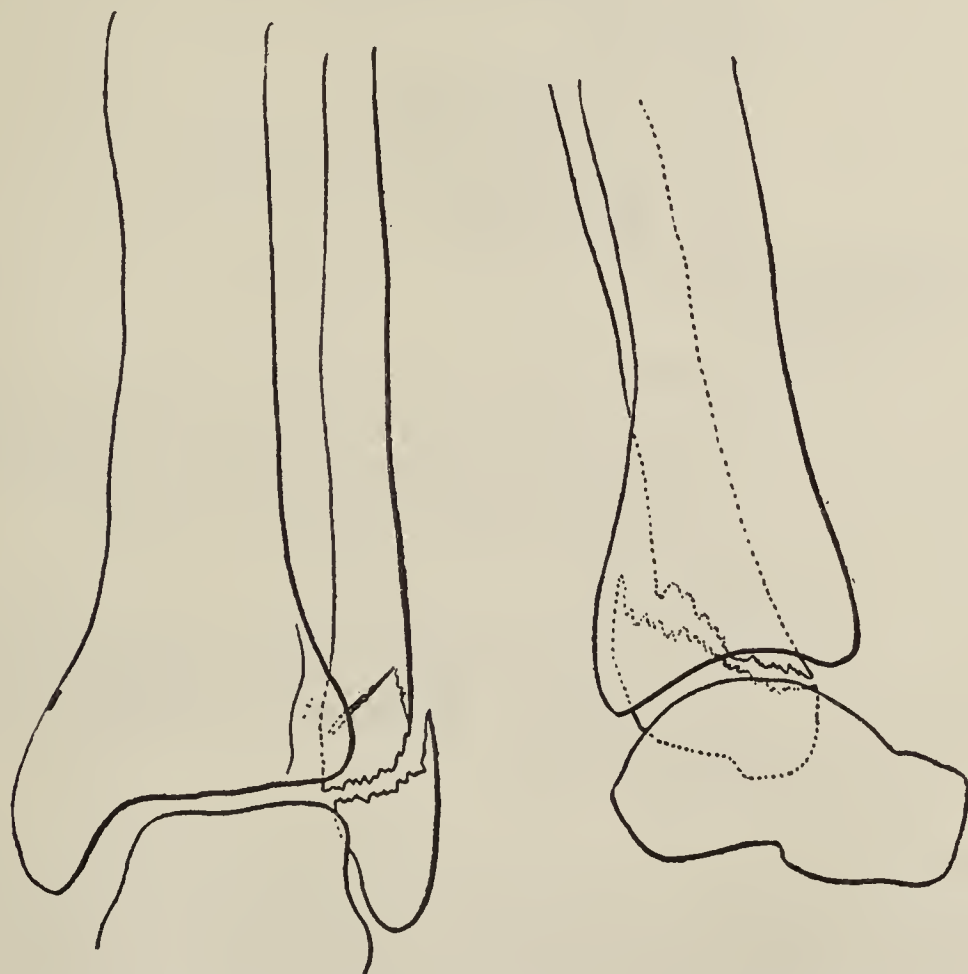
Fracture of fibula below inferior tibiofibular ligaments, with very slight obliquity, accompanied by rupture of the internal lateral ligament, as evidenced by lateral displacement of astragalus. This type of fracture is intermediate between the fracture by external rotation already discussed and the fracture by abduction. It is impossible from the roentgenogram alone to say to which of the two types such a fracture really belongs (A, II or B, II).
